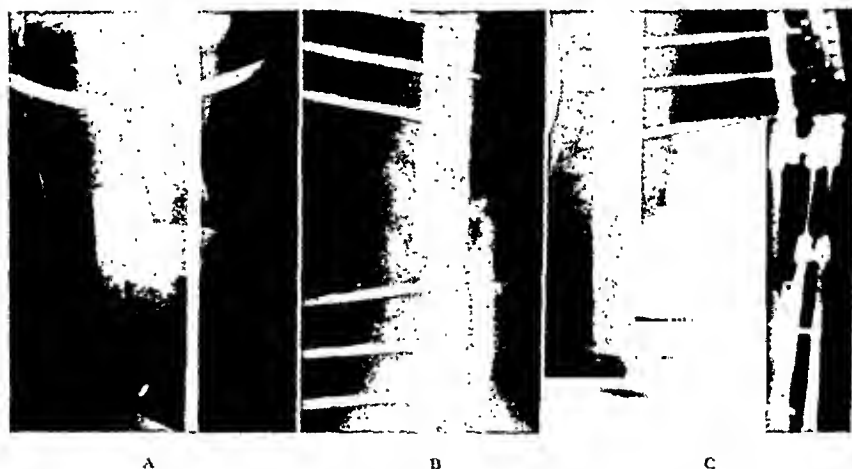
A, fracture of femur, middle third. B, longitudinal split in both upper and lower fragments not noted on first x-ray renders Haynes splint fixation inadequate. C, open reduction and split fragments held in position while pins are drilled through. Small vitallium plate used for additional security. Patient out of bed in three weeks. The splint was removed in three and one-half months at which time firm union was present.
